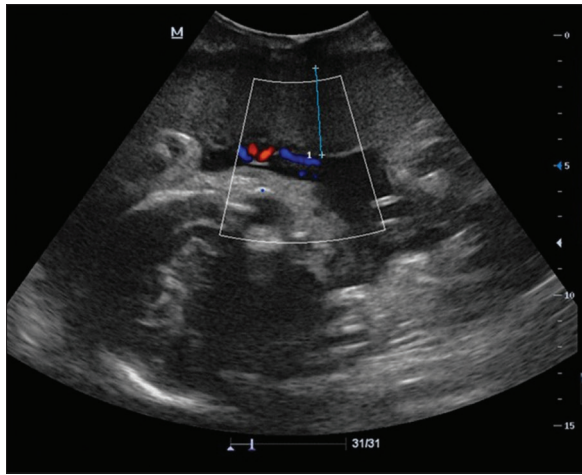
Duplex obstetric sonogram showing the measurement of placental thickness (in between calipers) measured from the chorionic plate to the basal plate at the level of umbilical cord insertion site (color-filled tubular structures at right angles to the chorionic plate)
